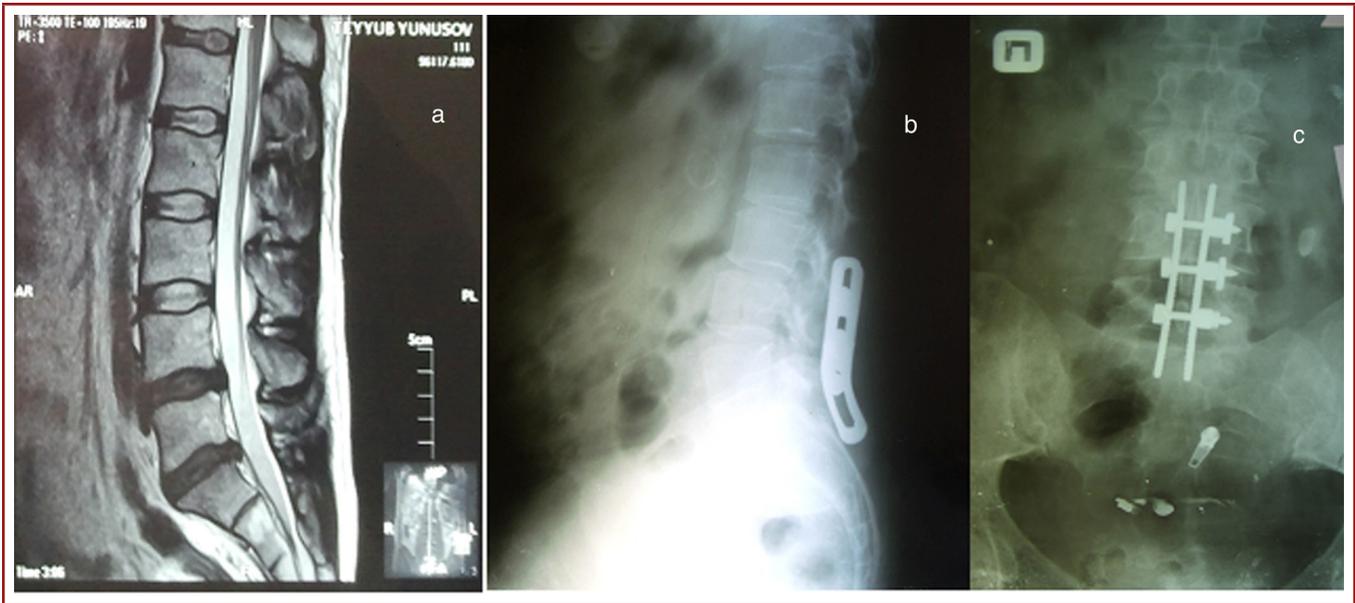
MR and X-ray pictures of the patient A.Y. with prolapsed two disks: *a)* MRT films of the low back region before the operation; *b)* X-ray picture low back region after the operation of implantation in side projection; *c)* X-ray picture low back region after the operation of implantation in direct projection.
